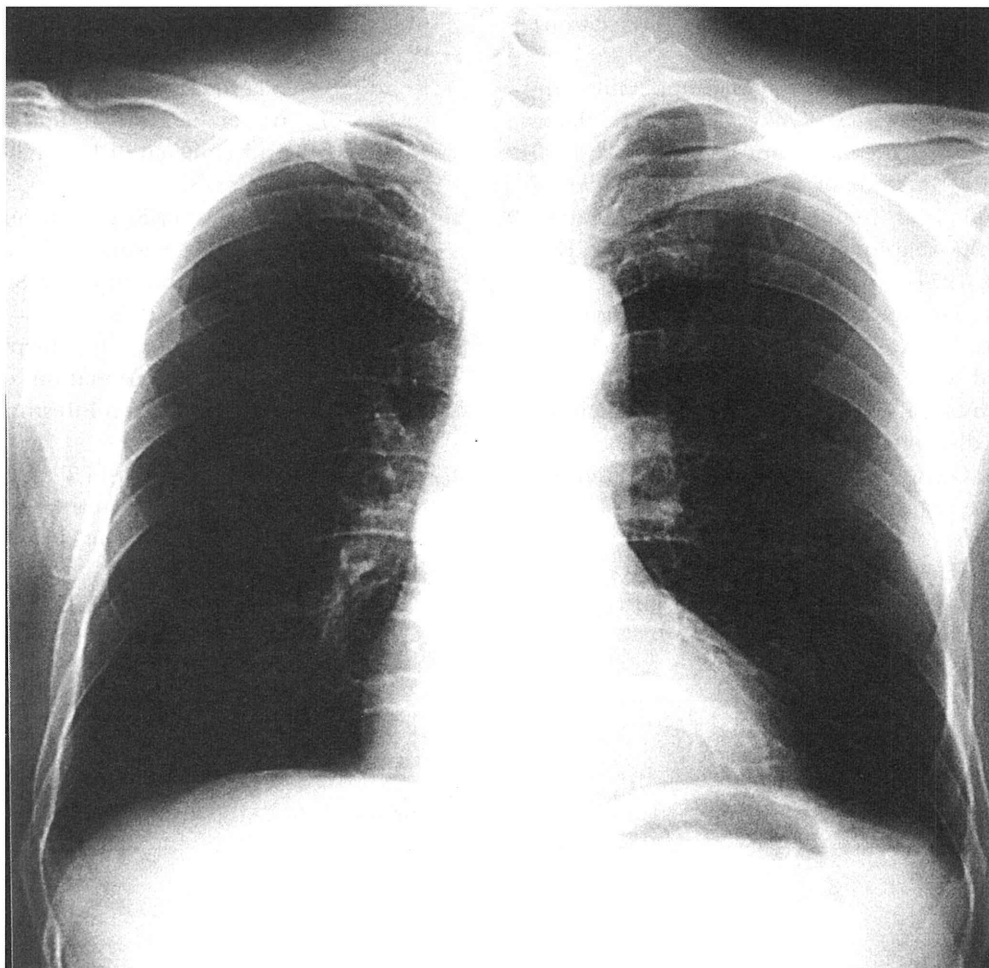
Chest X-ray film after the operation
